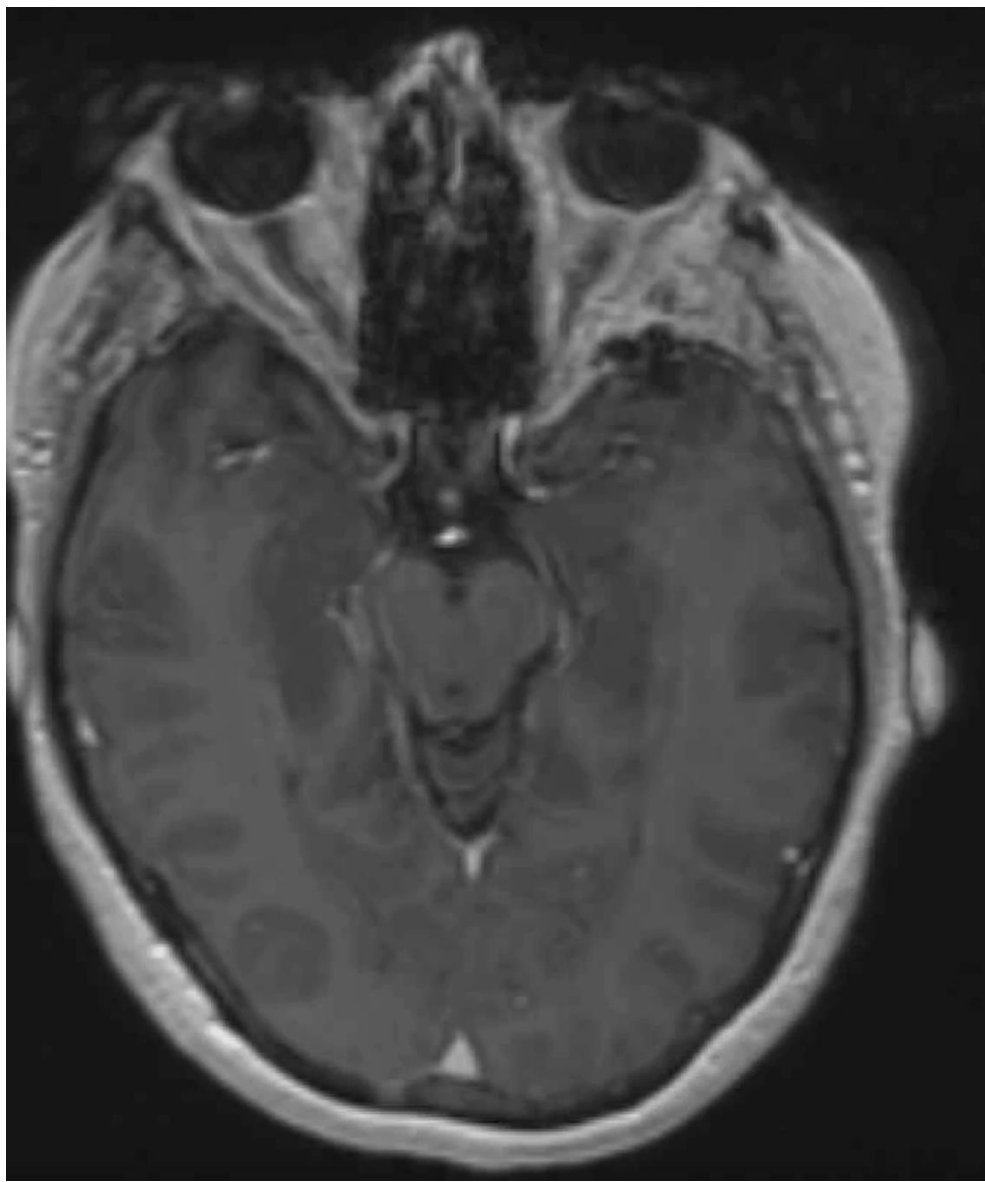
3 month axial T1 post-contrast MRI
